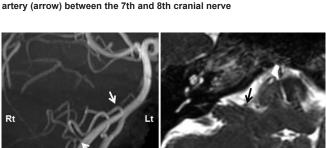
Case 4 (a) magnetic resonance angiography showing posterior inferior cerebellar artery duplication (arrows) on the right side, (b) axial three-dimensional fast imaging with steady-state acquisition magnetic resonance imaging showing distal posterior inferior cerebellar artery (arrow) compressing the root exit zone
